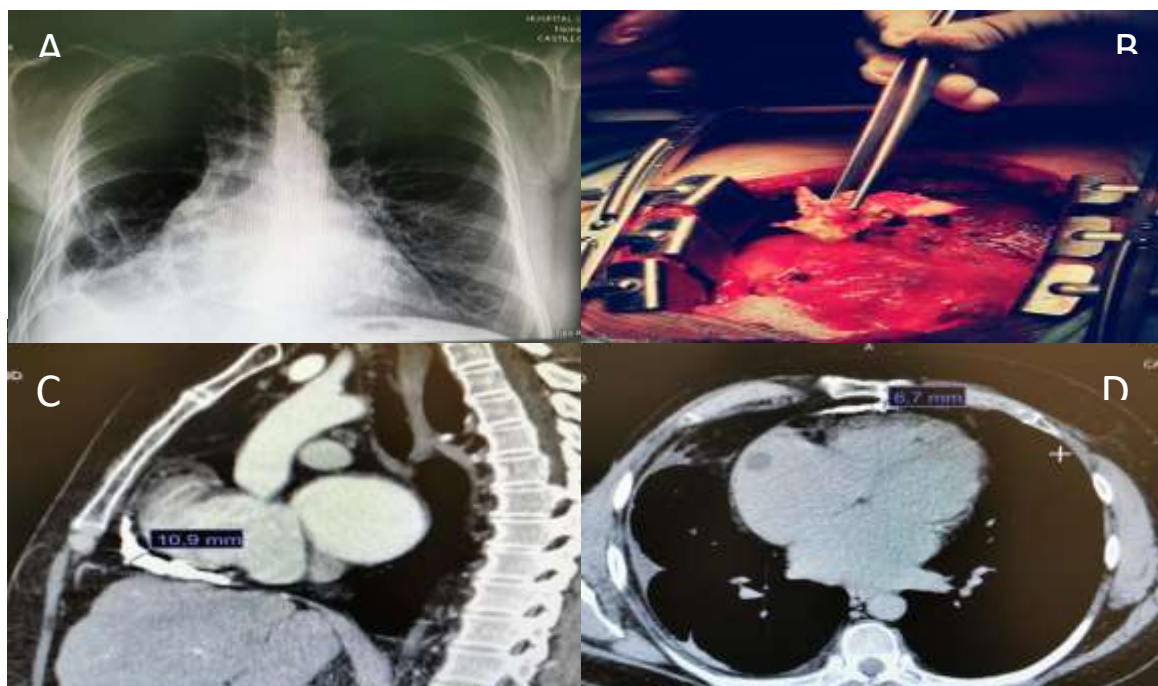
Chest X-ray: Pulmonary parenchyma increased parahilar mesh, with pulmonary fibrosis costodiaphragmatic and cardiophrenic arch preserved left and right effaced, ICT .52 grade I cardiomegaly, pericardial calcification (A), Pericardiectomy (B), Chest Computed Axial Tomography. Circumferential thickening of the pericardium (C and D).
